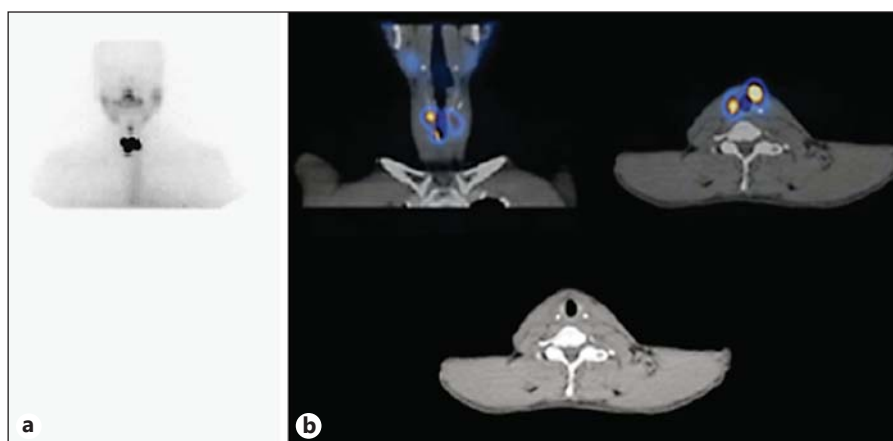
Lymph node downgrading: on the planar images (a), the multifocal uptake is graded to be a nodal disease. b SPECT/CT showed the corresponding uptake within the thyroid remnant.
